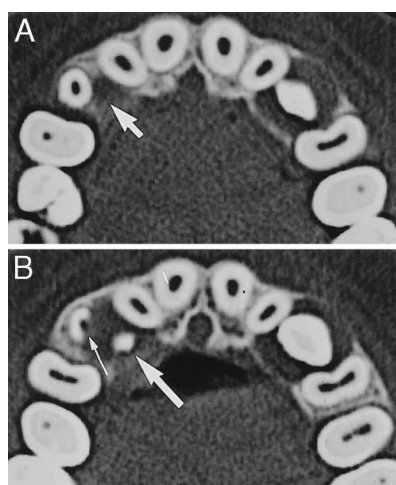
Findings in a 10-year-old boy on axial computed tomography (CT) scans. No. 13 is erupting lingually to No. 53 and distally to No. 12. The dental follicle of No. 13 is enlarged, and the roots of No. 53 and No. 12 are exposed on the sides facing the follicle (arrows). No. 53 has been resorbed close to the follicle (thin arrow), but the root of No. 12 is intact. There is a gap between No. 53 and the crown of No. 13. No. 23 is erupting within the dental arch and in contact with No. 22. The dental follicle is enlarged, and the periodontal contours of No. 22 and No. 24 facing the follicle have been resorbed. No root resorption of No. 22 or No. 24 can be seen.
